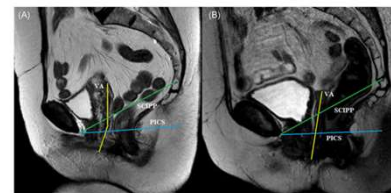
MRI photograph from vaginal axis (yellow line) after ASC (A) and vaginal VSF-M (B). It is shown the pelvic inclination correction system (PICS)—blue line and sacrospinous inferior pubic point line (SCIPP)—green line. ASC, abdominal sacrocolpopexy; MRI, magnetic resonance imaging; VSF-M, sacrospinous fixation surgery and anterior mesh.
